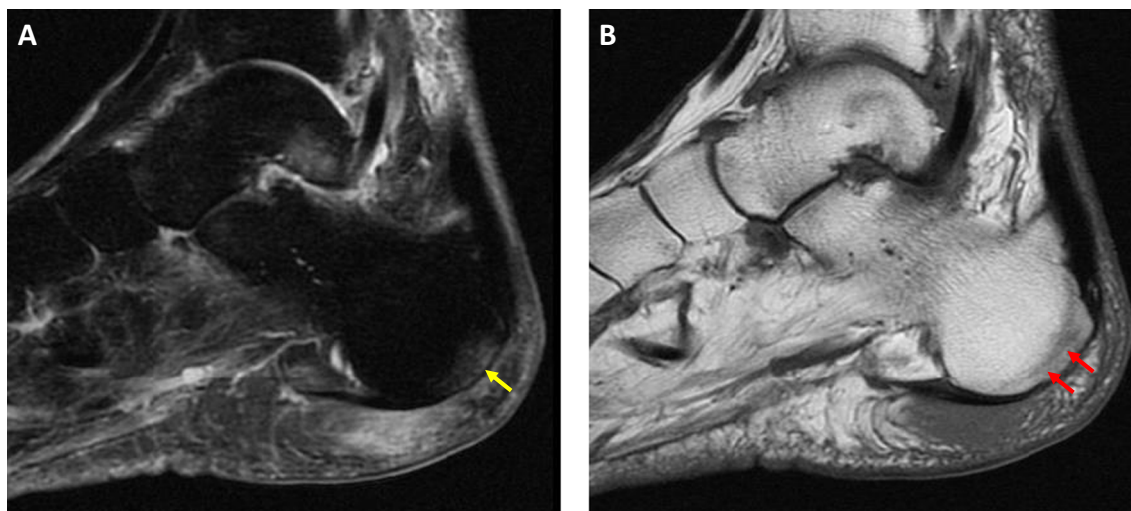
A 61-year-old woman with mild signal changes of the plantar calcaneus demonstrating the subcortical pattern of decreased signal on T1-weighted images, which is not associated with osteomyelitis. Sagittal STIR MR (a) demonstrates edema of the plantar fat pad and mild bone marrow edema of the calcaneus more posteriorly (yellow arrow). The
